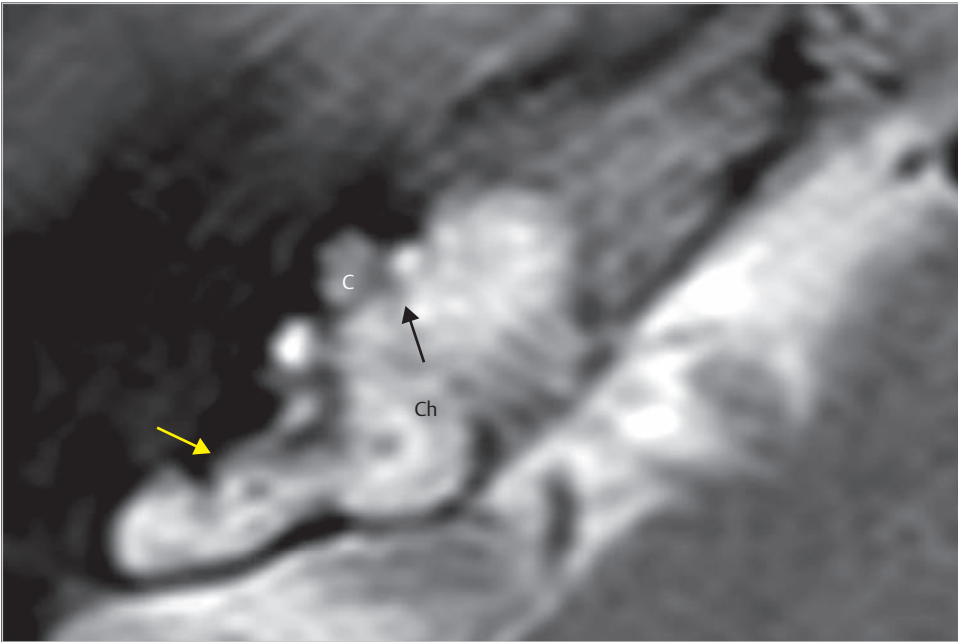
The preoperative MRI demonstrated high signal intensity of the cholesteatoma eroding the posterior semicircular canal (yellow arrow) and the cochlea (black arrow). C, cochlea; Ch, cholesteatoma.
